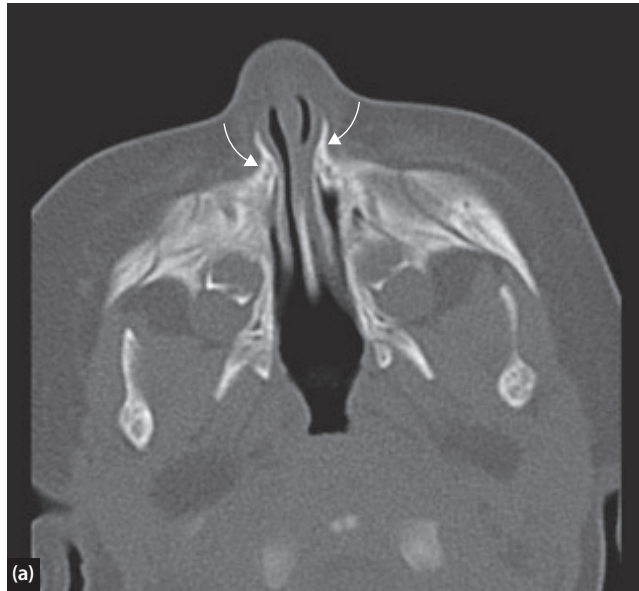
CT scan (axial view) of bilateral piriform aperture stenosis. Note the single central incisor.
